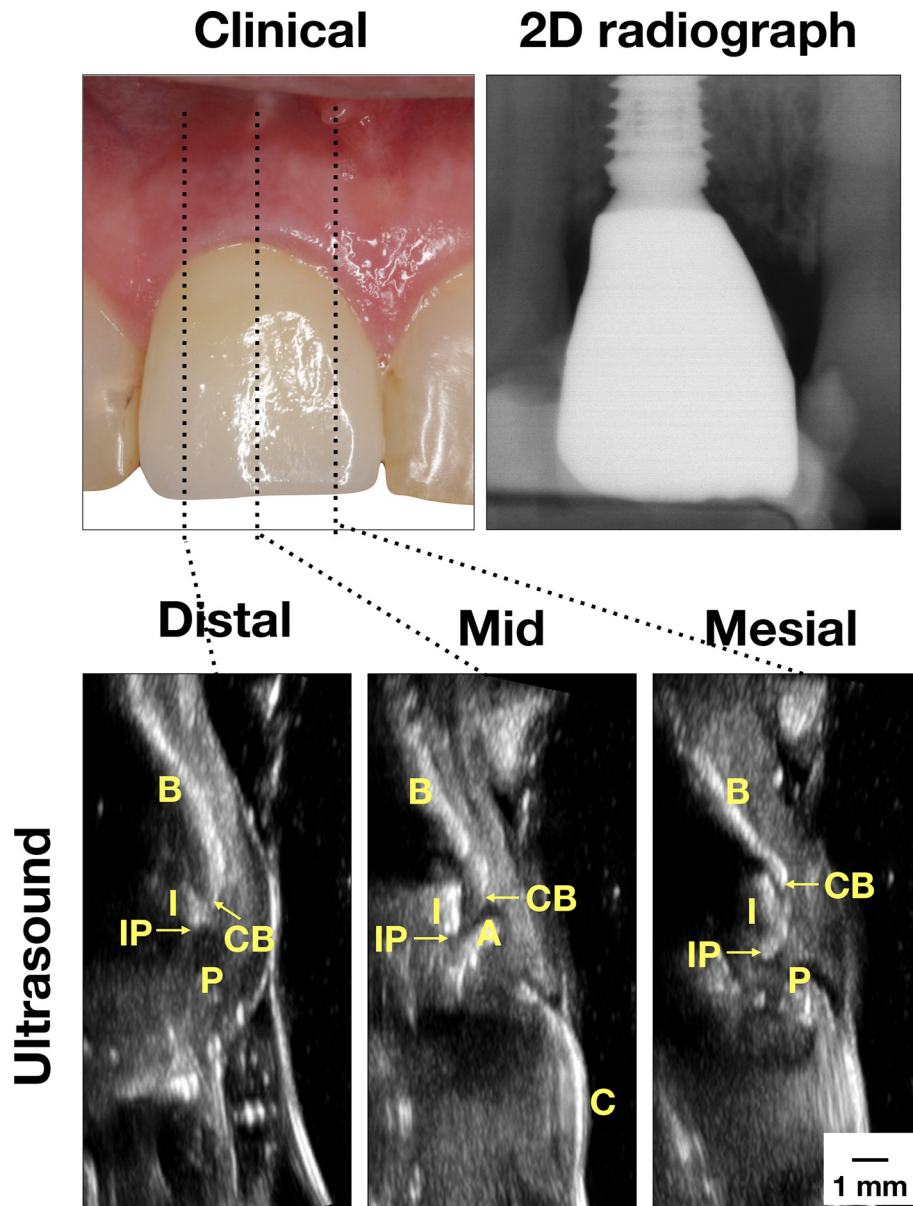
Case demonstration of a clinically healthy implant. Clinically, there are no signs of inflammation. Minimal bone loss was found on the peri-apical film. Ultrasound images on the mesial, mid-facial, and distal sites were presented. In the mid-facial image, the crown (C) surface is a bright line, connected to the abutment (A) and then the implant (I). The implant is readily identifiable because of the presence of the comet-tail artifact behind the implant. The bone surface (B) is yet another bright curved line. The junction between B and I is the CB. The junction between I and A is the IP. In the mesial and distal images, the bone and implant delineations are interpreted in the same way as in the mid-facial image. Additionally, the interdental papilla (P) is the structure between CB and the soft tissue surface. There is minimal implant fixture exposure, indicating normal bone level. CB, crestal bone; IP, implant platform.
